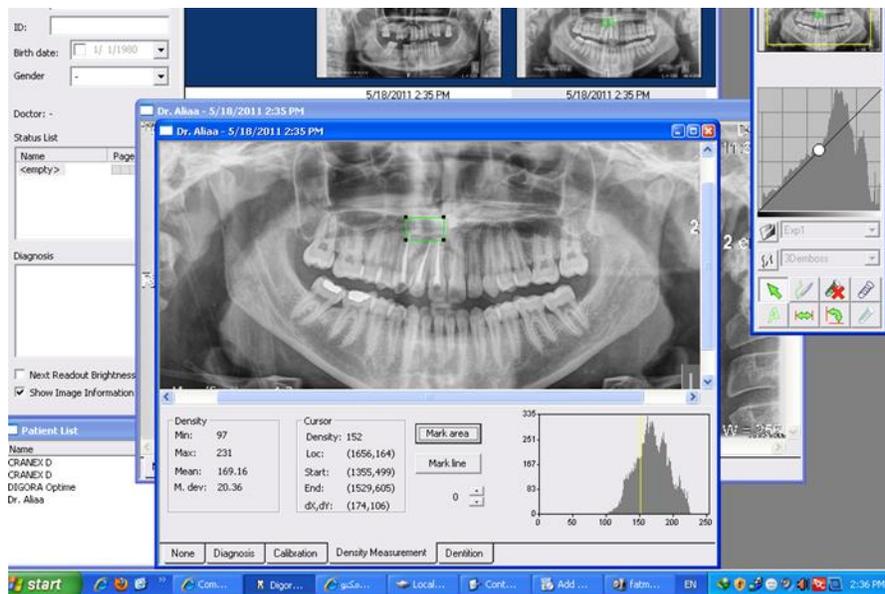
Photograph showing the screen print of the bone density measurement from orthopantomogram of the patient N using Digora software.
